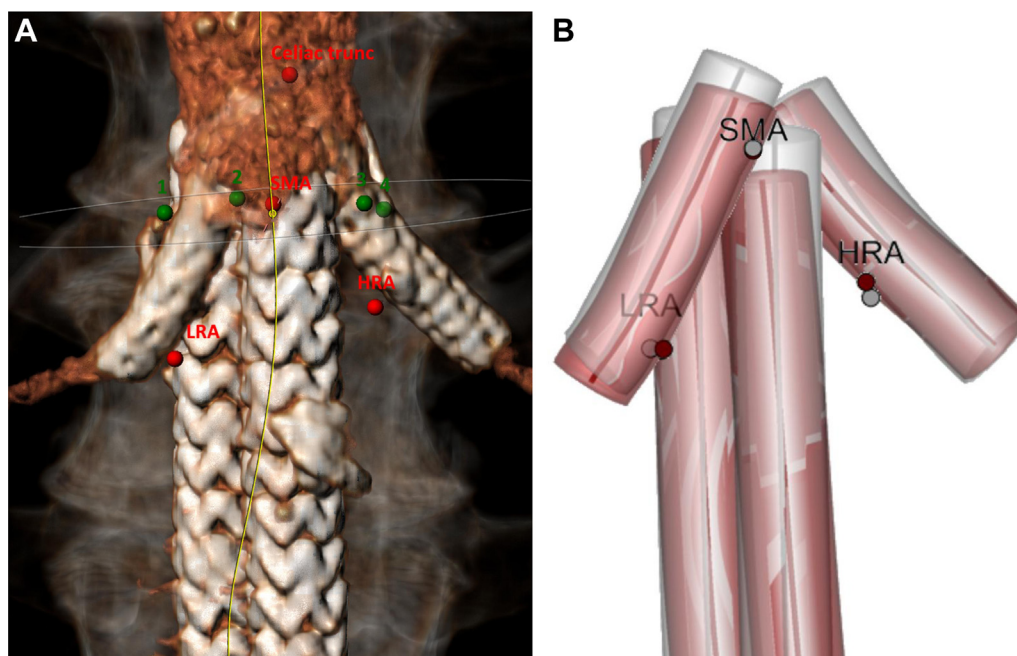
A, Reconstruction of Nellix stent frames and double chimney stent graft (ch-SG) configuration at 1-month follow-up (ie, ch-SGs in the left renal artery and superior mesenteric artery [SMA]). Reconstruction of Nellix stent frames and double ch-SG configuration at 1-month follow-up (ie, ch-SGs in both renal arteries). The *red markers*, needed for registration of the sequential computed tomography scans, are placed on the lower border of the celiac trunk, SMA, and highest (HRA) and lowest (LRA) renal artery. The *green markers*, needed to calculate the nonapposition surface, are located at the top of the circumference of the endobags (*markers 1-4*). The center lumen line (CLL) is shown in *yellow*. B, Anteroposterior reconstruction of the migration of the Nellix stent frames, left renal ch-SG, and right renal ch-SG, relative to the SMA orifice. The stent frames of the Nellix and ch-SGs at 1 month (*gray*) and 1 year (*red*) after chimney endovascular aneurysm sealing. The red and gray dots represent the anatomic landmarks at the 1- and 12-month follow-up, aligned via rigid registration. The misalignment of the markers resulted from tissue deformation between the follow-up evaluations.
